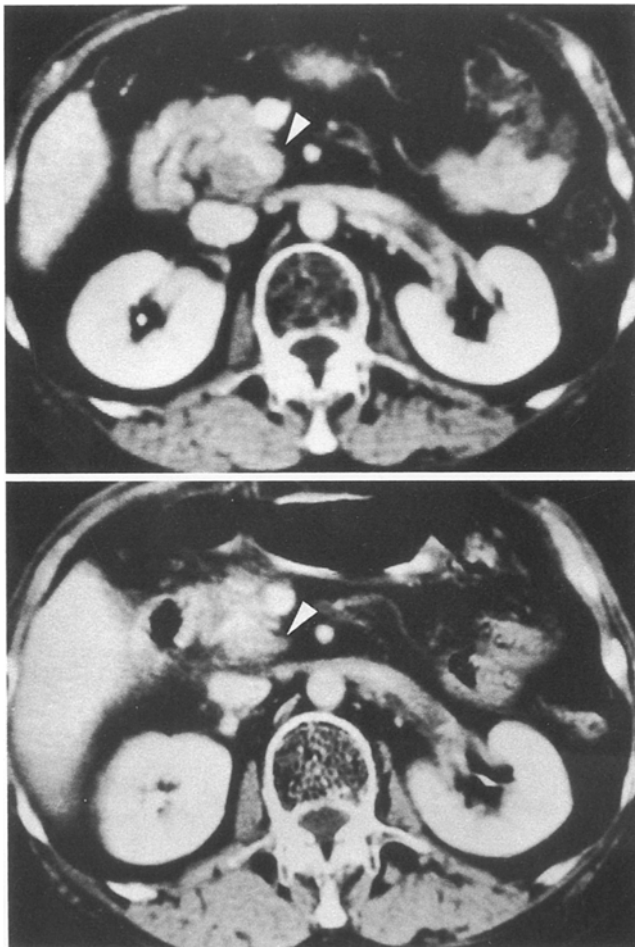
Computed tomography (CT) findings of case 3. Swelling of the posterior pancreaticoduodenal lymph node can be seen (*top*), which showed marked regression after the completion of irradiation therapy (*bottom*)
